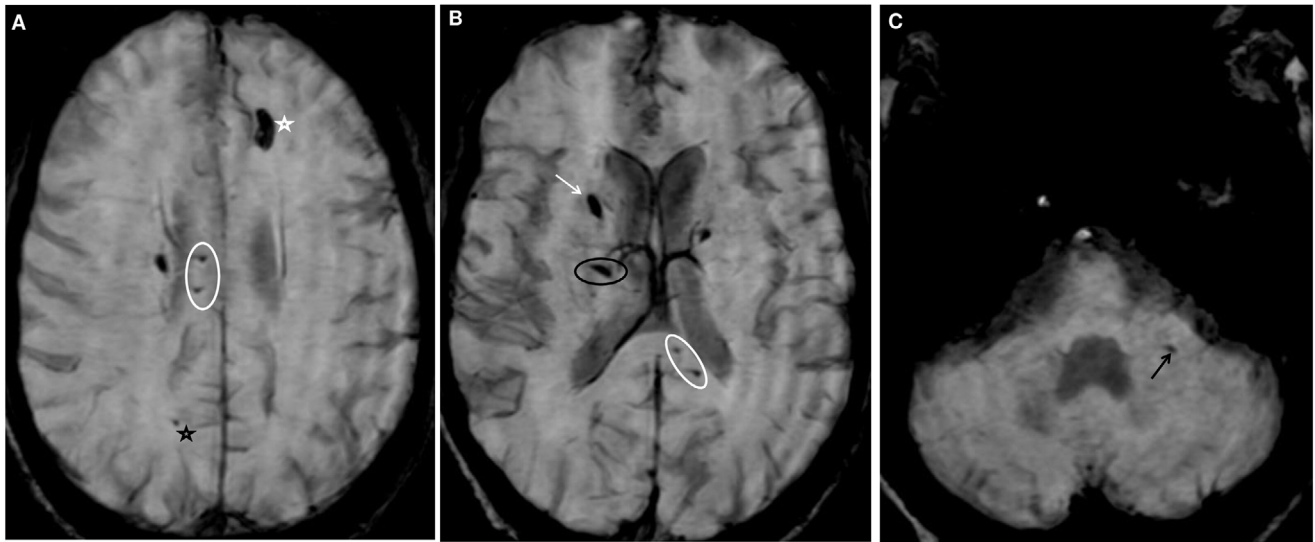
Brain MRI findings of a 66-year-old man include multiple microbleeds, involving the corpus callosum (white ellipse in A and B), the anterior limb of the right internal capsule (white arrow in B), the left middle cerebellar peduncle (black arrow in C), the basal ganglia (black ellipse in B), subcortical white matter (black star in A), as well as one left frontal macrobleed (white star in A). Similarly to the previous patient, some of the lesions appear linear (black ellipse in B).
